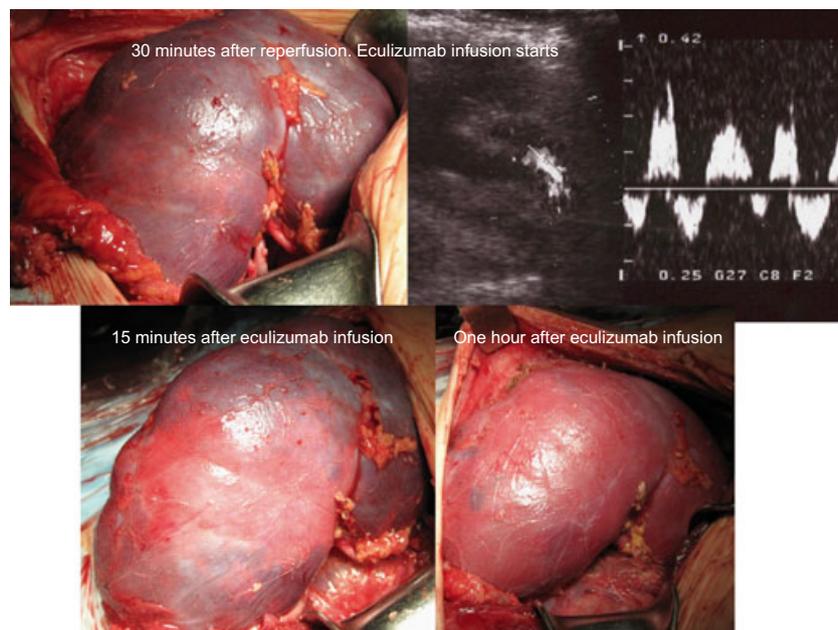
Kidney graft appearance at 30, 45, and 90 min after graft reperfusion. Doppler ultrasound results when graft discoloration occurred.
